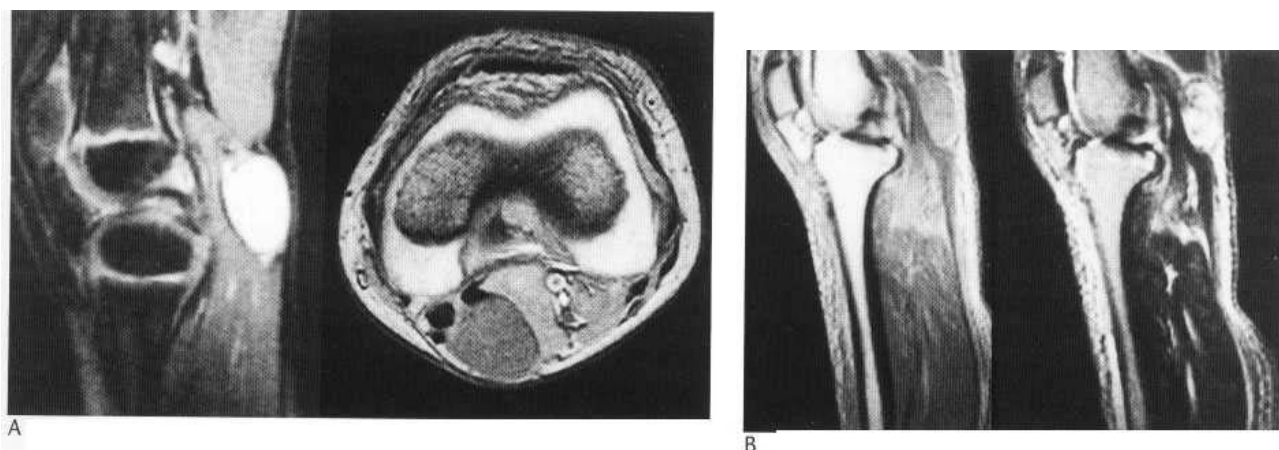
Baker's cyst. (A) Sagittal fat-suppression (left) and axial T₁-weighted gradient-echo (right) MR sequences. The sagittal image demonstrates a well-defined and intact Baker's cyst posterior to the knee joint in this child. The axial image shows the medial situation of the Baker's cyst and demonstrates its origin between the tendons of the medial gastrocnemius head and distal semimembranosus muscles. (B) T₁- and T₂-weighted MR images showing a posteriorly situated cyst, seen to contain debris. The leak disrupts the adjacent musculature.
